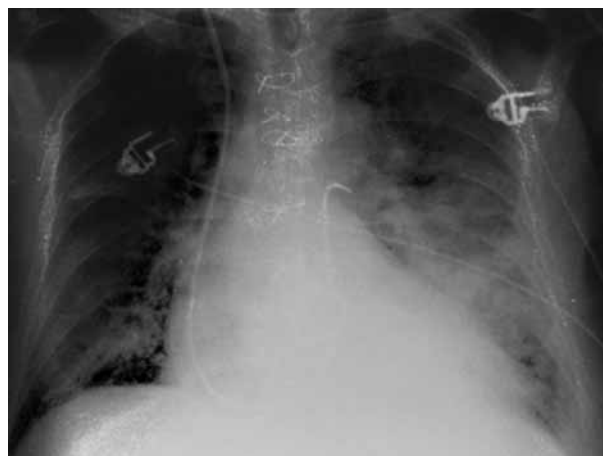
Chest radiograph performed early after admission showing cardiomegaly and predominant left-sided pulmonary edema.
